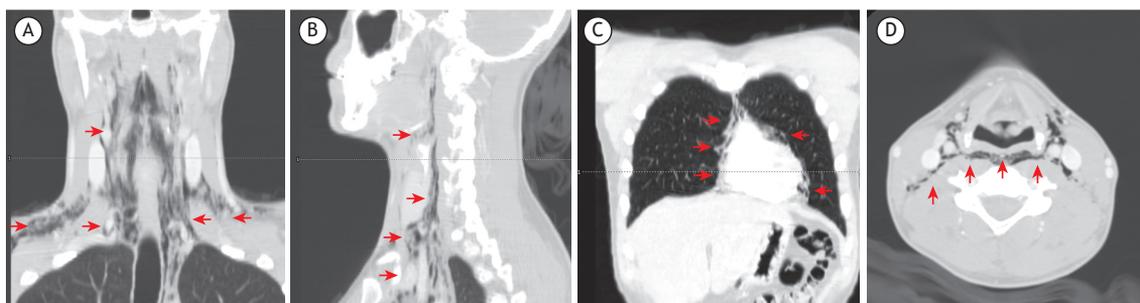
CT scans showing massive spontaneous pneumomediastinum: coronal view (in A) and sagittal view (in B) of subcutaneous emphysema dissecting through the cervical fascia; massive pneumomediastinum (in C); and subcutaneous emphysema reaching the base of the skull (in D).
